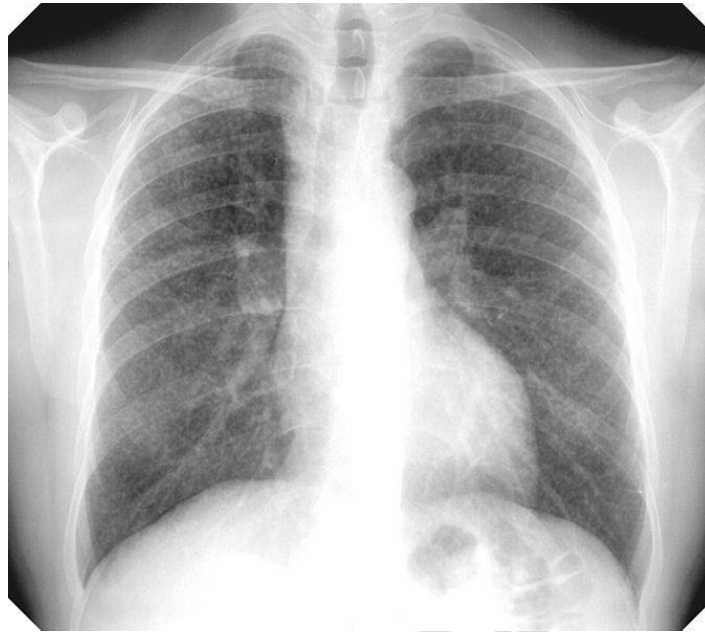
Survey X-ray of patient T.
